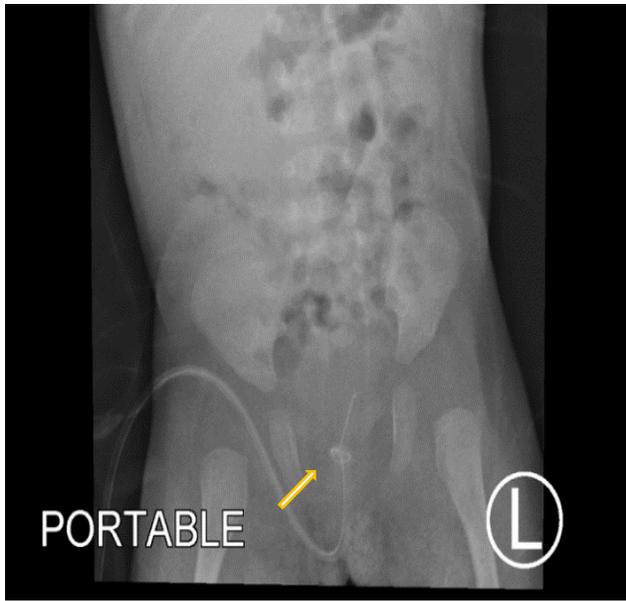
An X-ray, showing the knotted catheter in the bladder of a late preterm female infant (Arrow).
